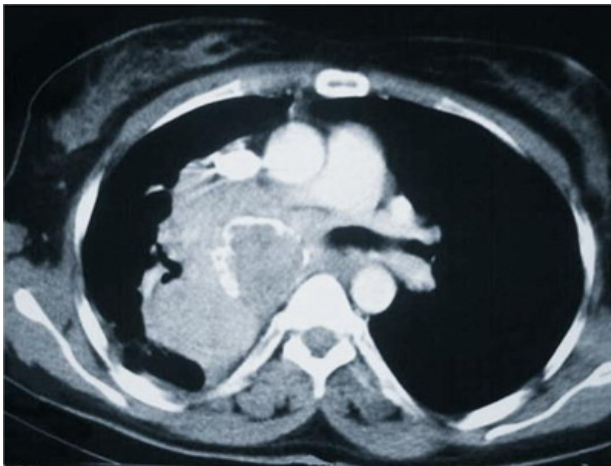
Case 3: CT scan (mediastinal window) shows large solid mediastinal mass that extends to the right lung. Calcification is also present.
